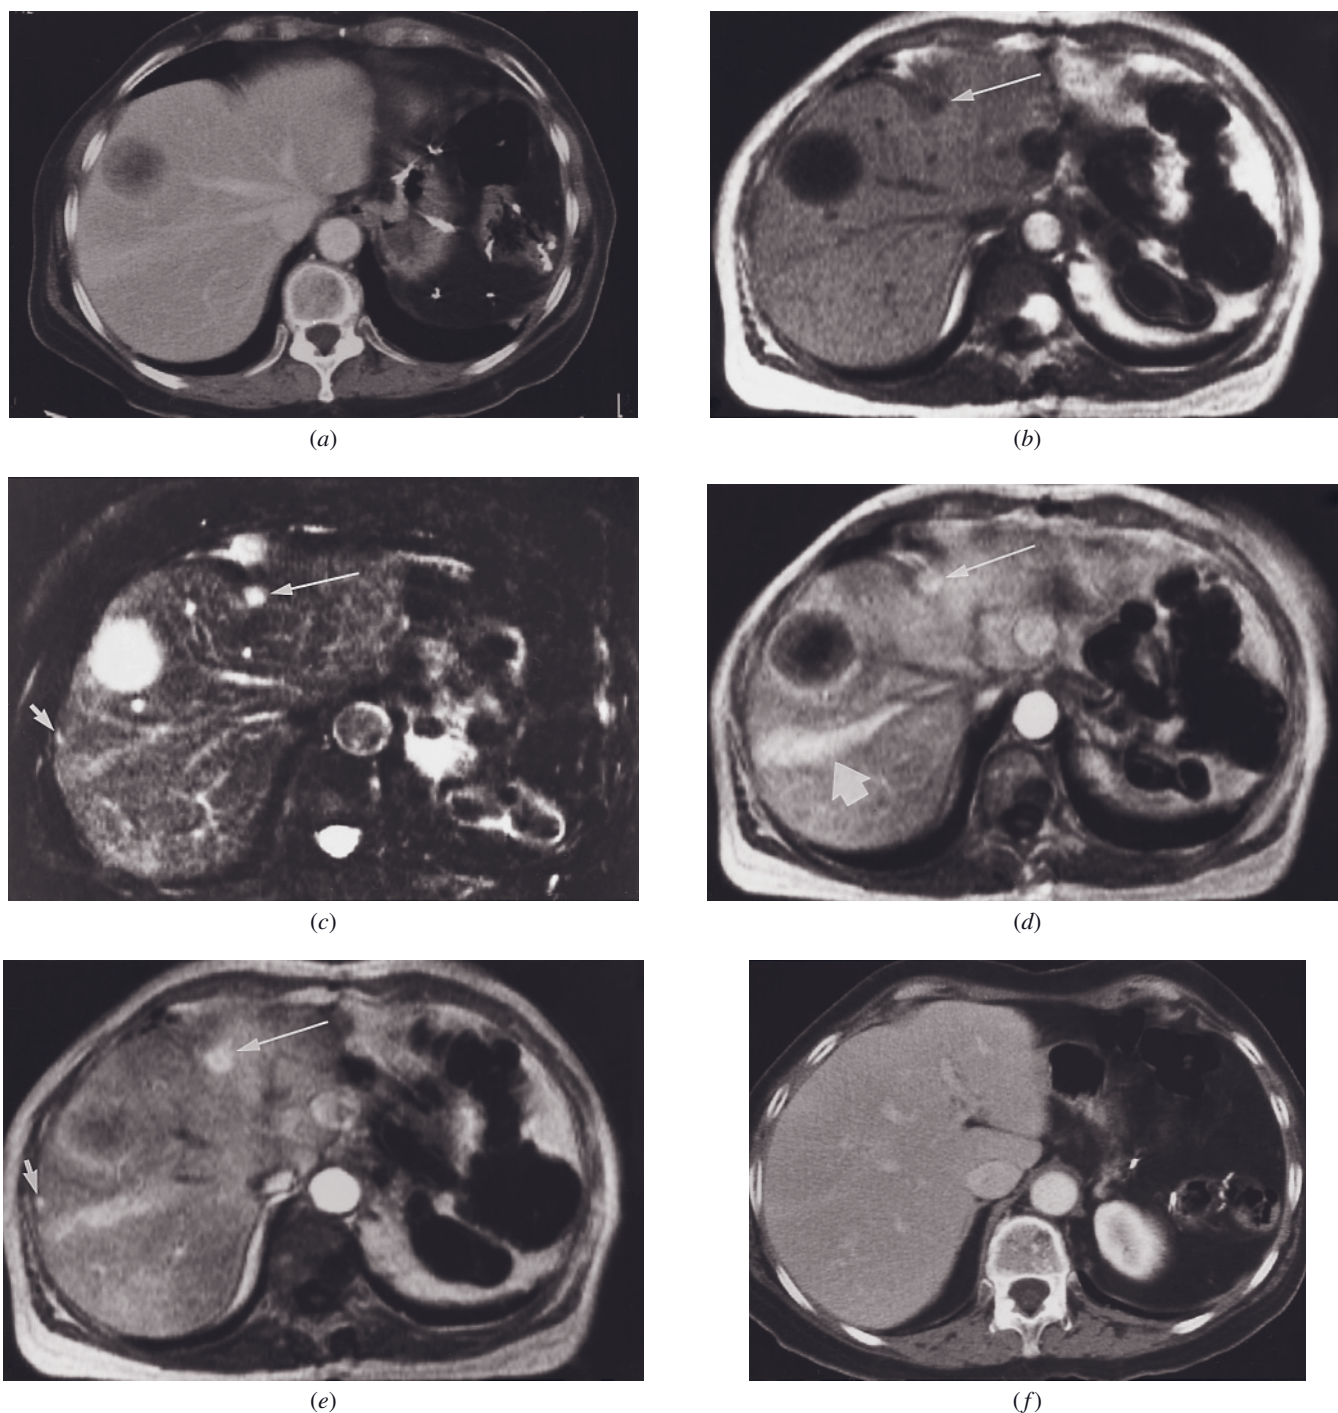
Hypervascular liver metastases from small bowel leiomyosarcoma. Dynamic contrast-enhanced CT (*a*), SGE (*b*), fat-suppressed T2-weighted SE (*c*), and immediate postgadolinium SGE (*d*, *e*) images. A 4-cm metastasis was appreciated on the CT imaging study (*a*). The SGE image (*b*) demonstrated a second 8-mm lesion in the lateral segment (arrow, *b*). The fat-suppressed T2-weighted SE image (*c*) demonstrated the lesion in the lateral segment (long arrow, *c*) and a 5-mm subcapsular lesion in the anterior segment (short arrow, *c*). Immediate images (*d*, *e*) demonstrate ring enhancement around the 4-cm metastases and uniform enhancement of the 8-mm metastases in the lateral segment (long arrow, *d*, *e*) and of the 5-mm subcapsular metastases (short arrow, *e*). Wedge-shaped transient increased enhancement is present in the posterior segment (large arrow, *d*), which is also faintly apparent on the CT image (*a*). Dynamic contrast enhanced CT (*f*), SGE (*g*), fat-suppressed T2-weighted SE (*h*), and immediate (*i*) and 45-s (*j*) postgadolinium SGE images from the midhepatic level in the same patient. A 7-mm metastasis is present in the right lobe
